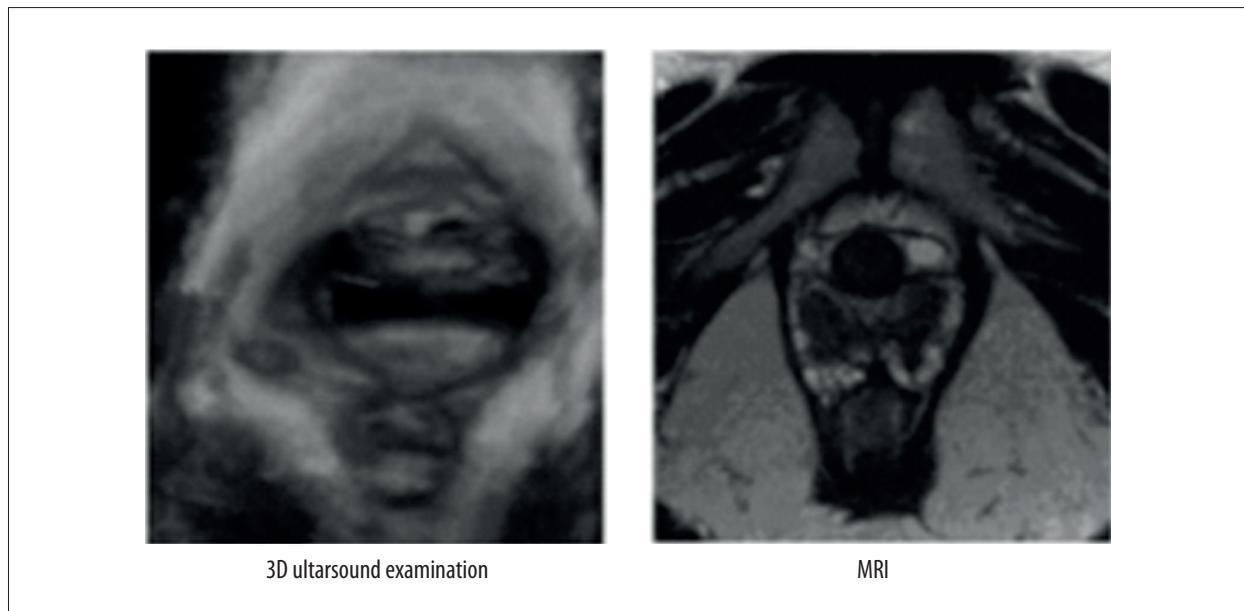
3D ultrasound and MRI examination of the transverse image, anterior and posterior diameter of pelvic diaphragm, transverse diameter, and area of the pelvic diaphragm in the resting state.
